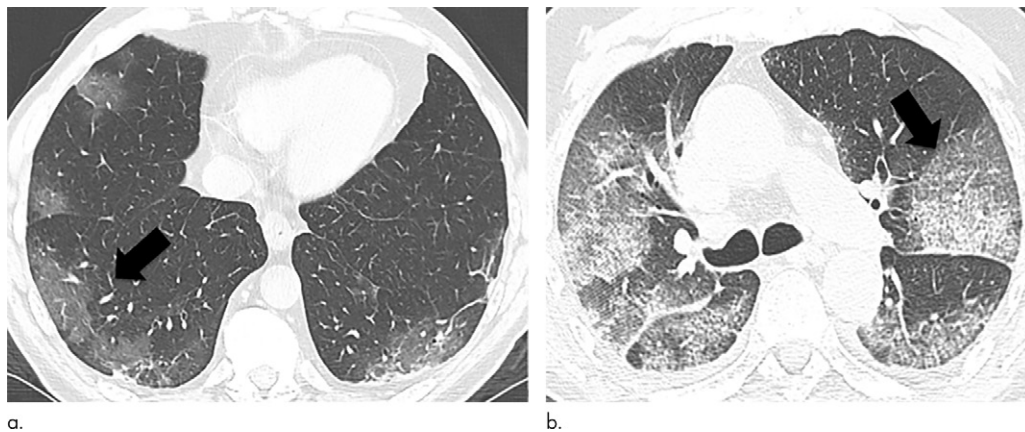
Images in patient with coronavirus disease 2019 (COVID-19) pneumonia. (a, b) Typical CT aspect of COVID-19 pneumonia: initial phase of disease with areas of ground-glass opacity peripherally (arrow in a); severe phase of disease with diffuse crazy paving pattern (arrow in b). Pleural effusions are absent.
